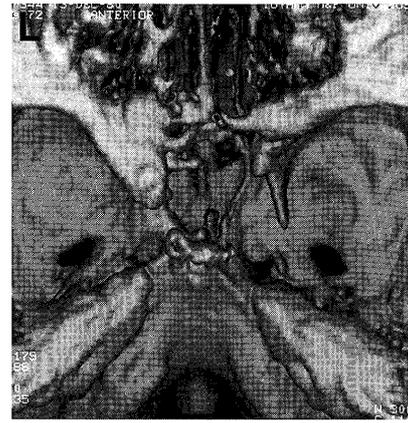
Three-dimensional computed tomography scan of the skull base.
